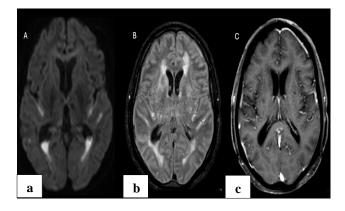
Bacterial meningitis with ventriculitis (a) DWI (b=1000) shows layering, diffusion-restricting debris in bilateral occipital horns (ADC values 0.5×10⁻³ mm²/s) and Sylvian fissures, (b) FLAIR imaging reveals hyperintense signal in sulcal spaces and ventricular system bilaterally, and (c) T1 post-contrast demonstrates leptomeningeal and ependymal enhancement consistent with meningoventriculitis. CSF analysis showed WBC 2,500/mm³ with 90% neutrophils.
